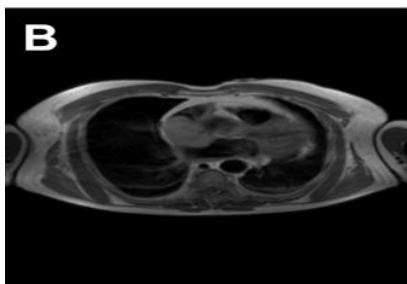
January 2011 - An MRI scan was suggested in order to clarify the nature of the finding demonstrated by CT. The BB T1 sequences above confirmed the right atrial mass, partially involving superior vena cava.
